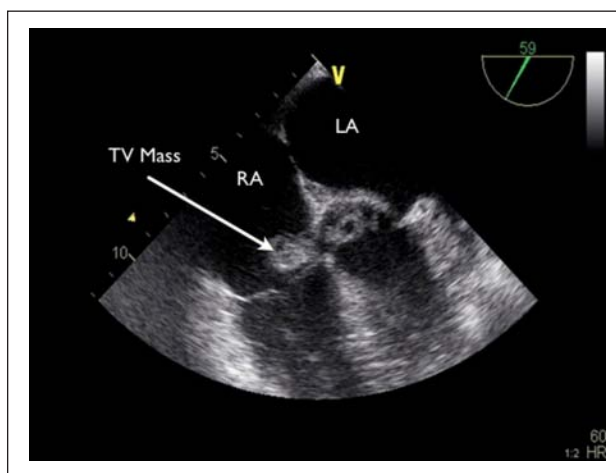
Transesophageal echocardiography mid-esophageal image demonstrating a large vegetation associated with the tricuspid valve (TV)
